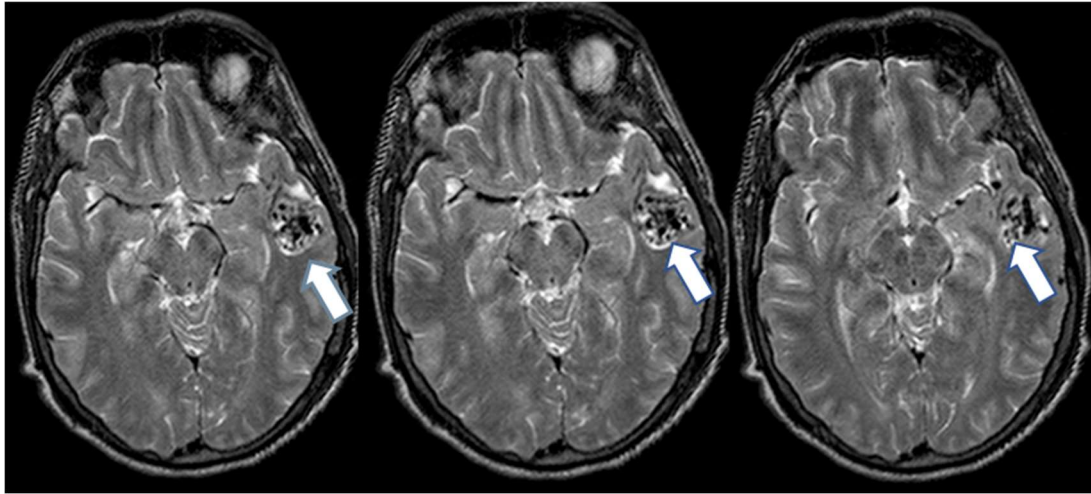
Axial T2-weighted Magnetic Resonance Imaging (MRI) image showing a left temporal AVM (Spetzler-martin grade III)
